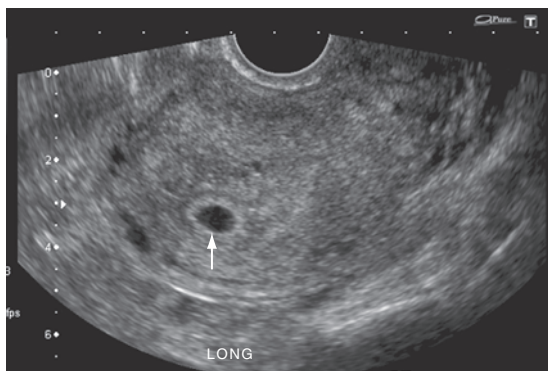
Chorio-decidua. A transvaginal sonogram with arrow pointing to a thick echogenic circumferential ring of echoes around anechoic gestational sac. This represents a collection of embryological tissues called chorio-decidua.
